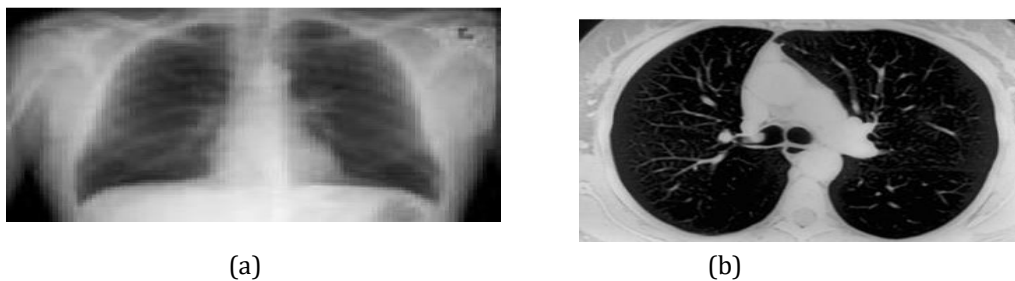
Chest images (a) Anterior-Posterior Chest X-ray (b) Transversal CT slice
